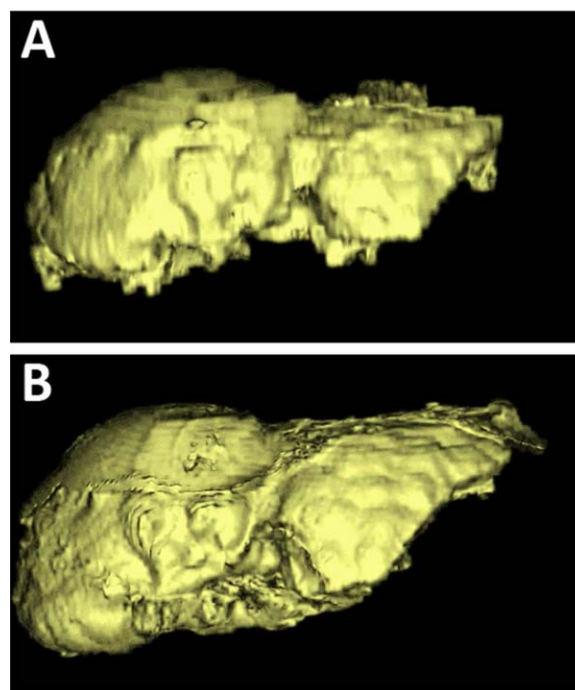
Liver volume measurement before and after partial shunt embolization. (A) The CT-reconstructed liver volume measured at 873 mL prior to partial shunt embolization. (B) CT-reconstructed liver volume measured at 1,346 mL ~9 months after partial shunt embolization.
